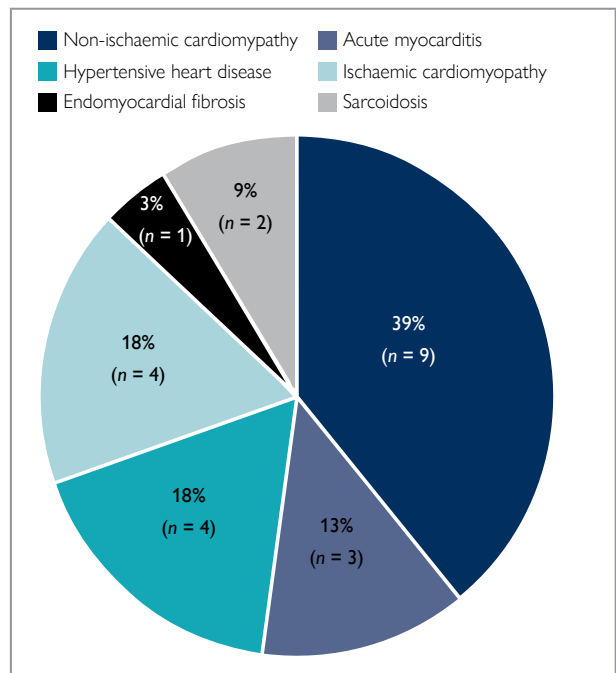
Diagnoses of patients who underwent cardiac magnetic resonance imaging.
